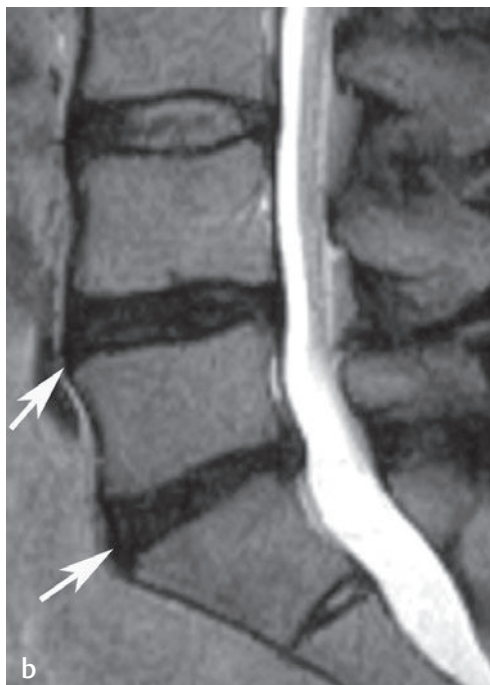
Lumbar degenerative disc disease. The degree of disc T2-weighted signal and height loss should be evaluated and graded as (a) mild, (b) moderate, or (c) severe lumbar degenerative disc disease (arrow[s] on each).[†]
